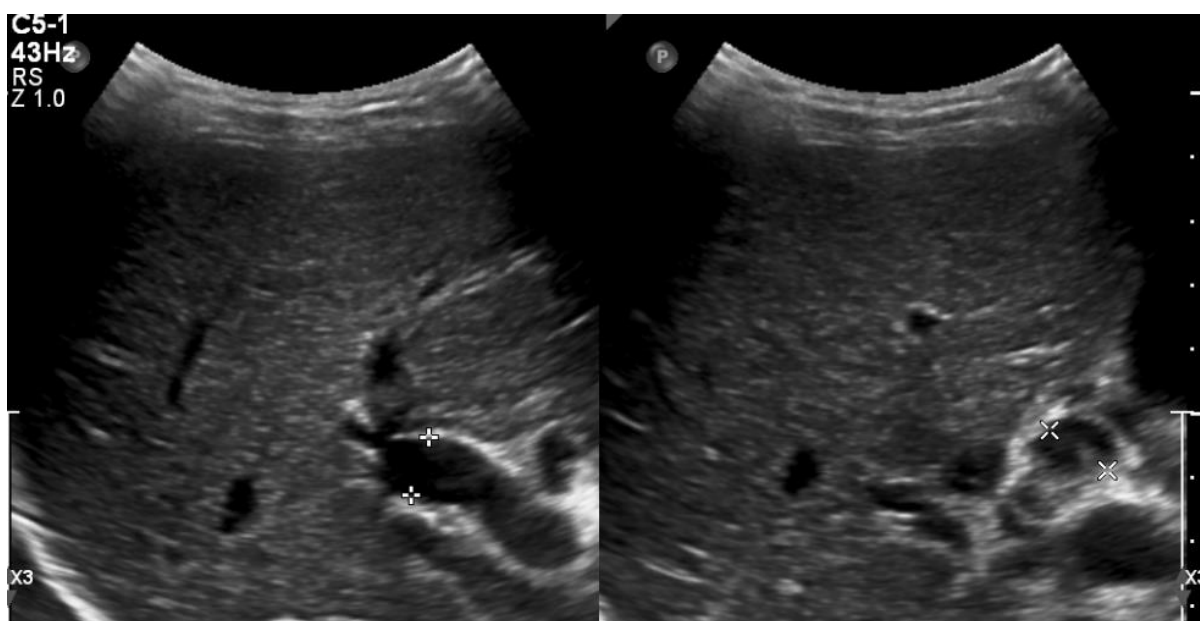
Ultrasound abdomen shows common dilated hepatic duct and left hepatic duct with filling defect and septations within the left hepatic duct.
